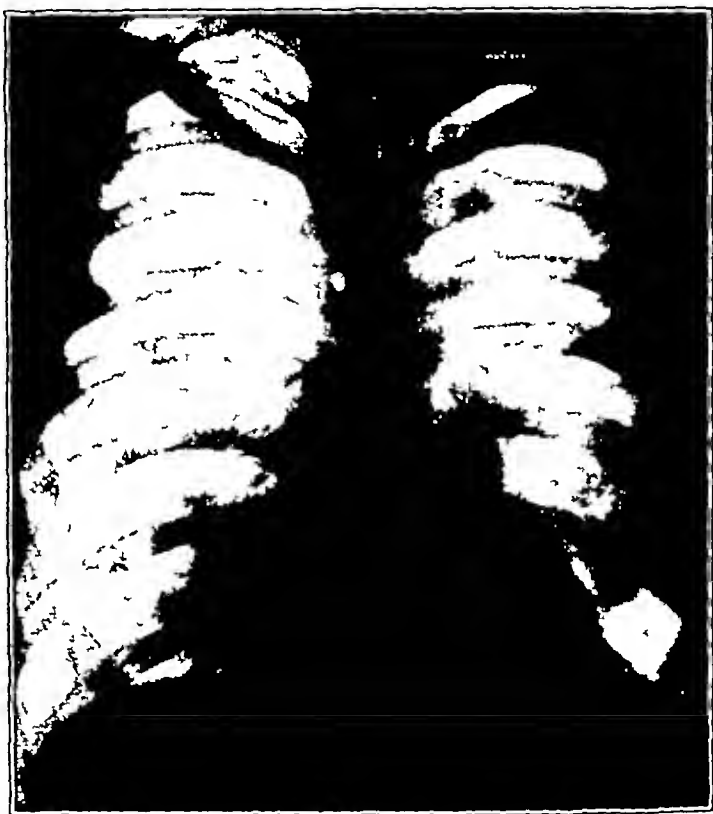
(case 3) —Partial collapse of both lungs, 800 cc of air was withdrawn from the right side before the roentgenograms were taken
